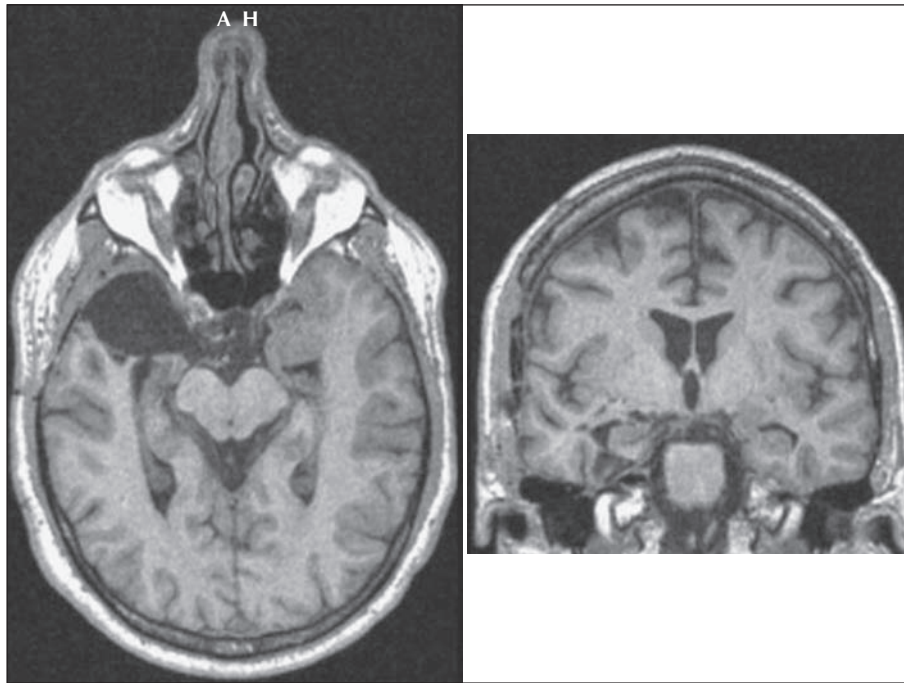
Postoperative MRI demonstrating the superselective resection of the temporal pole, uncus and amygdala with preservation of the hippocampus and parahippocampal gyrus.
